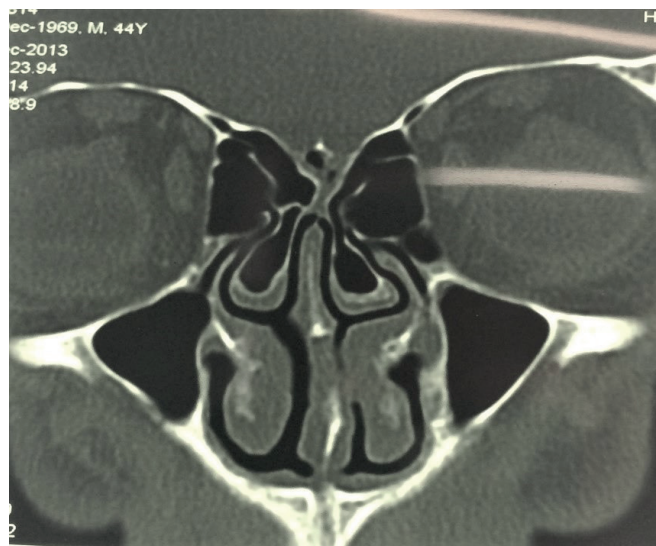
A coronal CT image of a concha bullosa.
